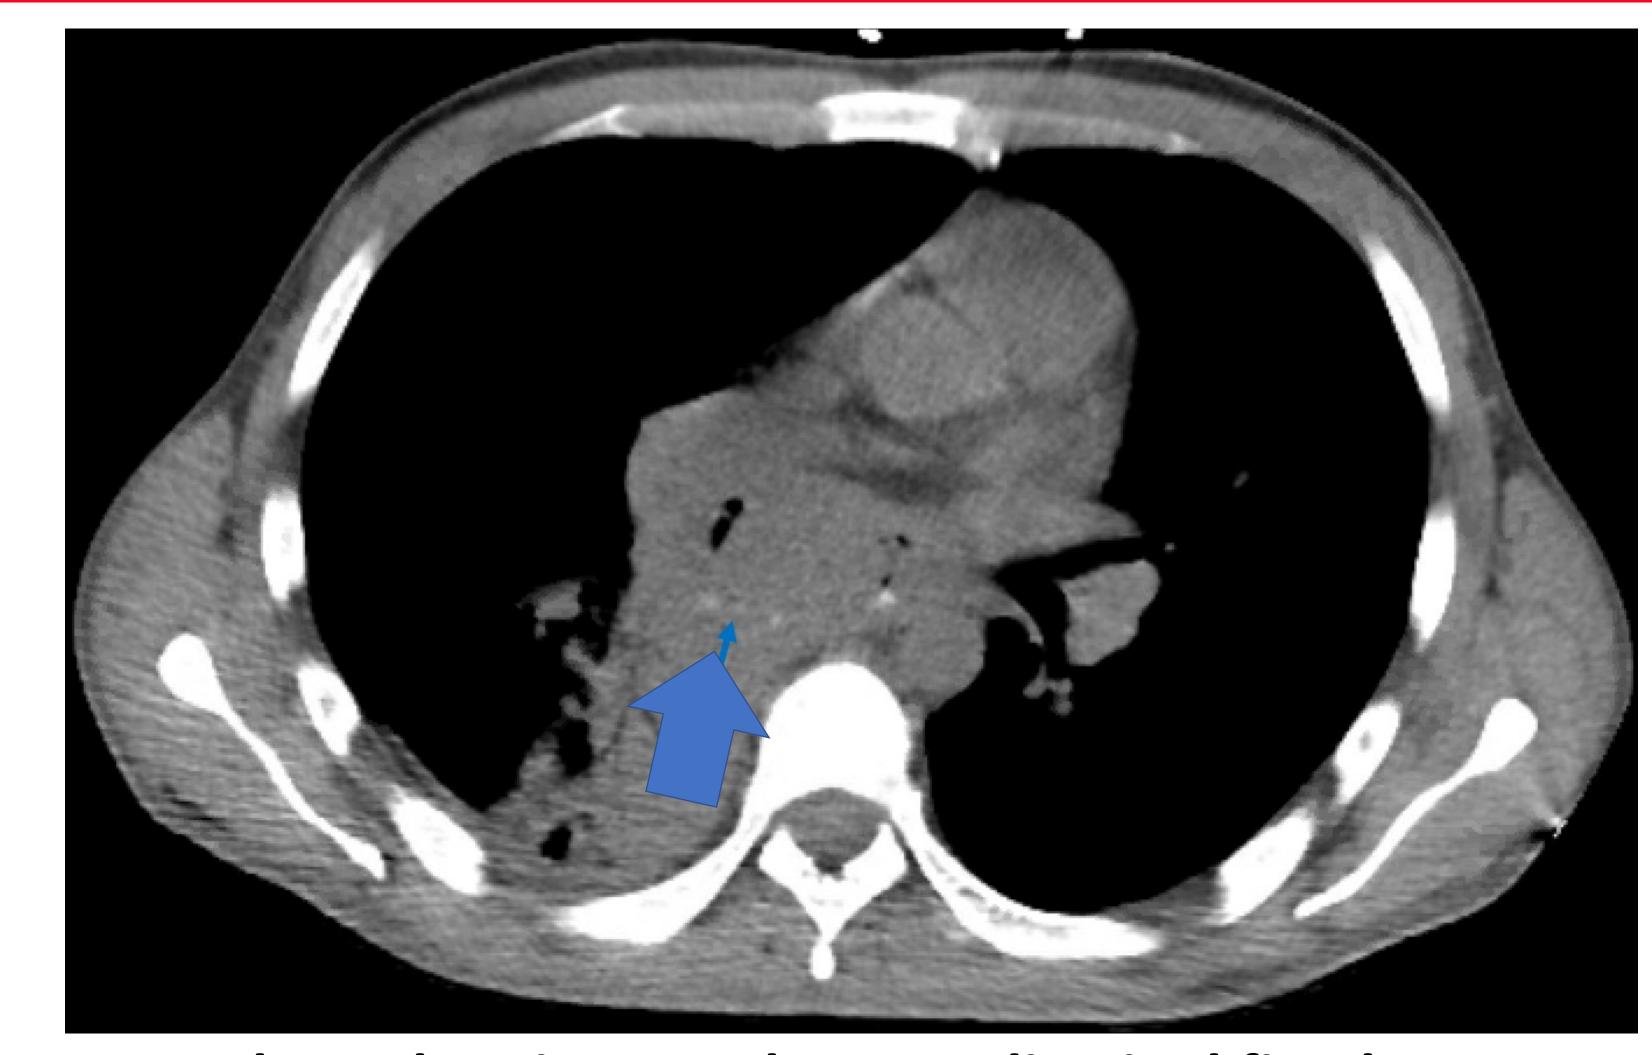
CT Chest showing esophagomediastinal fistula.
